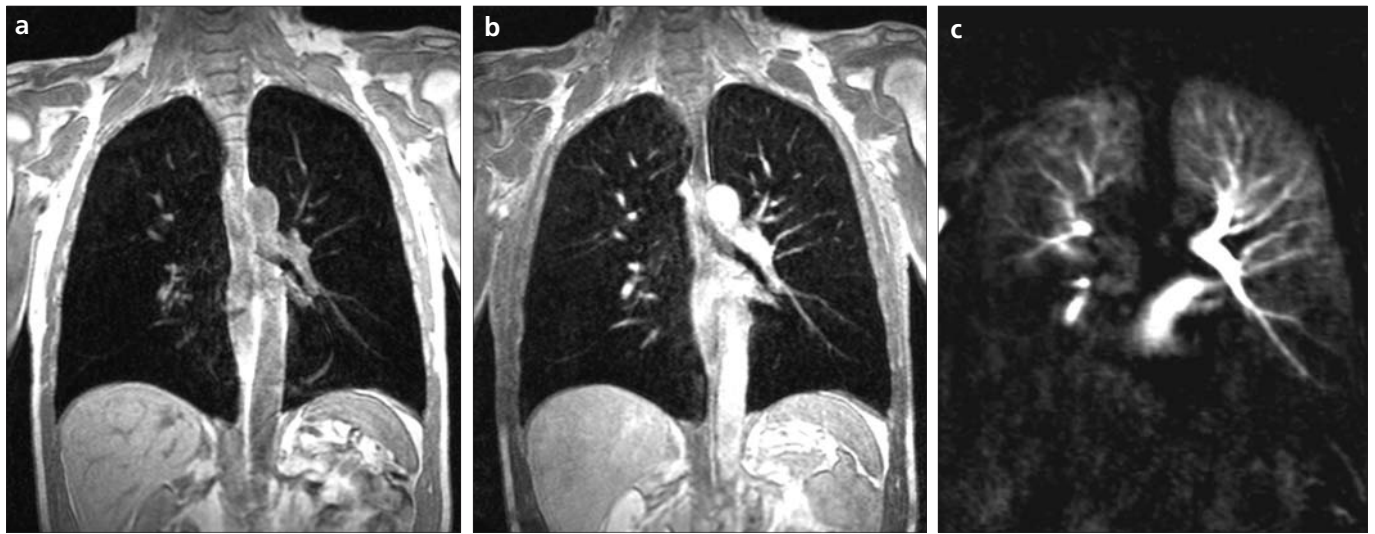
a–c. Coronal T1-weighted three-dimensional gradient echo sequence (a) in a 67-year-old patient with COPD stage IV due to excessive cigarette smoking. Emphysematous areas are hardly resolved due to low signal intensity. The fat saturated contrast-enhanced sequence (b) reveals areas of low contrast uptake corresponding to extensive emphysema, predominantly of the lower lobes in this patient. MRI perfusion imaging (c) confirms large perfusion defects of the right upper and both lower lungs. Due to hypoxic vasoconstriction, perfusion can be regarded as a blueprint of ventilation. Courtesy of A. Anjorin, Heidelberg Thoracic Imaging Platform, Heidelberg, Germany.
